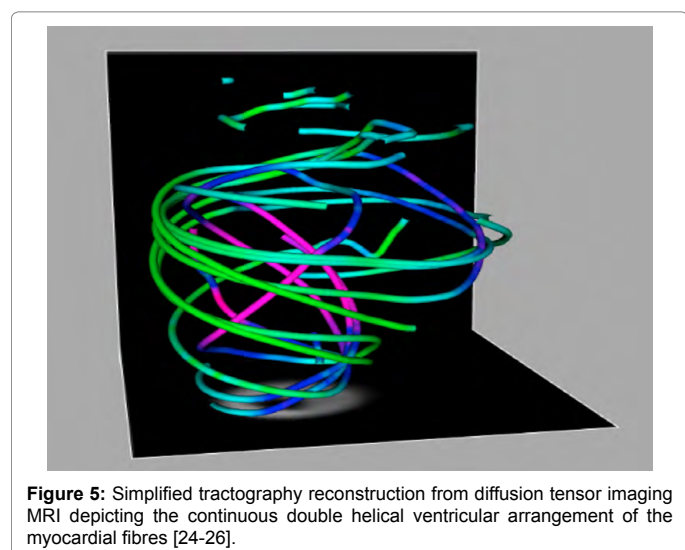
Simplified tractography reconstruction from diffusion tensor imaging MRI depicting the continuous double helical ventricular arrangement of the myocardial fibres [24-26].
